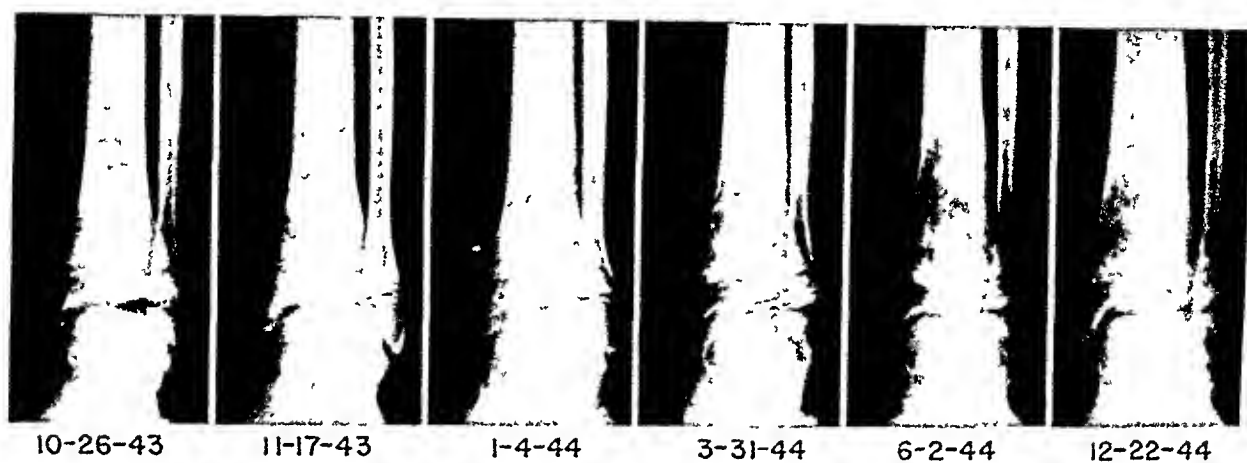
Showing bony changes occurring in Case 4. 10-26-43. Small area of rarefaction on the outer aspect of tibia, just above the ankle, with a very tiny break in the cortex. No periosteal reaction on medial aspect, lower third. 11-17-43. Mottling of lower one-fourth of tibia due to irregular areas of rarefaction. Very slight periosteal reaction on medial aspect, lower third. 1-4-44. Mottling has increased in lower portion of tibia and periosteal reaction is now very well defined. Also slight periosteal elevation on outer aspect of fibula, distal one-fourth. 3-31-44. More extensive bone rarefaction and periosteal reaction than on previous roentgenograms. Several breaks in tibial cortex now easily seen. 6-2-44. Less mottling than previously and almost complete disappearance of the periosteal reaction. No sequestration anywhere. 12-22-44. All mottling has disappeared and no periosteal reaction remains. Healing of the infection appears complete.
